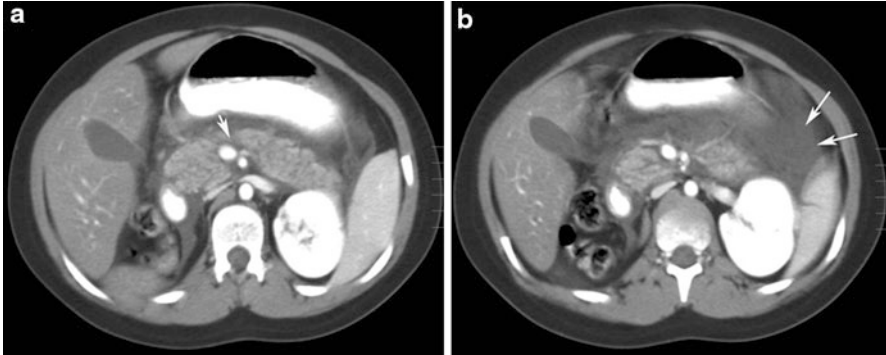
Axial CT images in a 6-year-old child with bruises from abuse, showing pancreatic laceration (*arrow* in figure a) and peripancreatic hyperdense fluid/blood (*arrows* in figure b)
